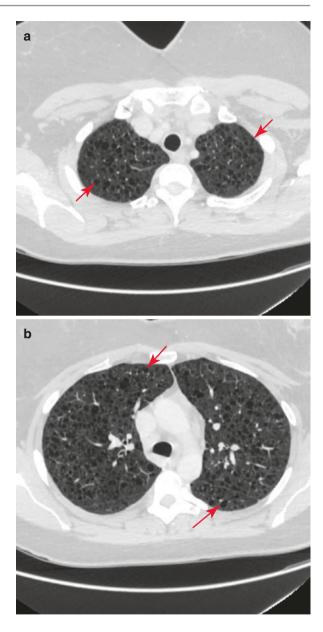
(a–d) HRCT of the lungs: bilateral multiple small evenly distributed cysts with a fine wall
